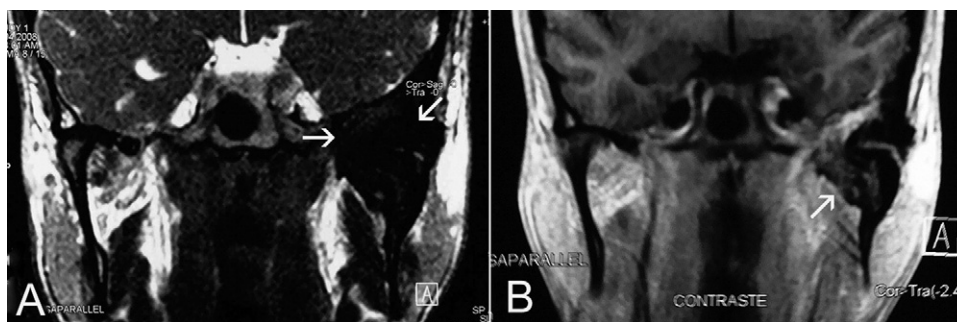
Magnetic resonance imaging. A, Coronal T2-weighting, showing a low-signal lesion compressing the adjacent structures, including dura mater and medial and lateral pterygoid muscles (arrows). B, The lesion also displays some areas of intermediate signal in close proximity to the adjacent dura mater (arrow, coronal T1-weighting with contrast).
